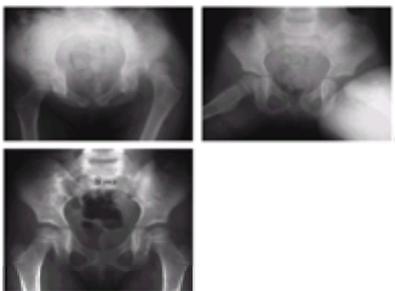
A: A girl 13 years and 11 months of age sustained a left posterior hip dislocation in a motor vehicle accident. B: Computed tomography scan after reduction showed intraarticular bony fragments. C: At open reduction and capsulorrhaphy, the bony fragments were removed. Suture anchors were used to reattach capsule to bone. Ten months postinjury, there is no sign of avascular necrosis. Heterotopic ossification is seen.
